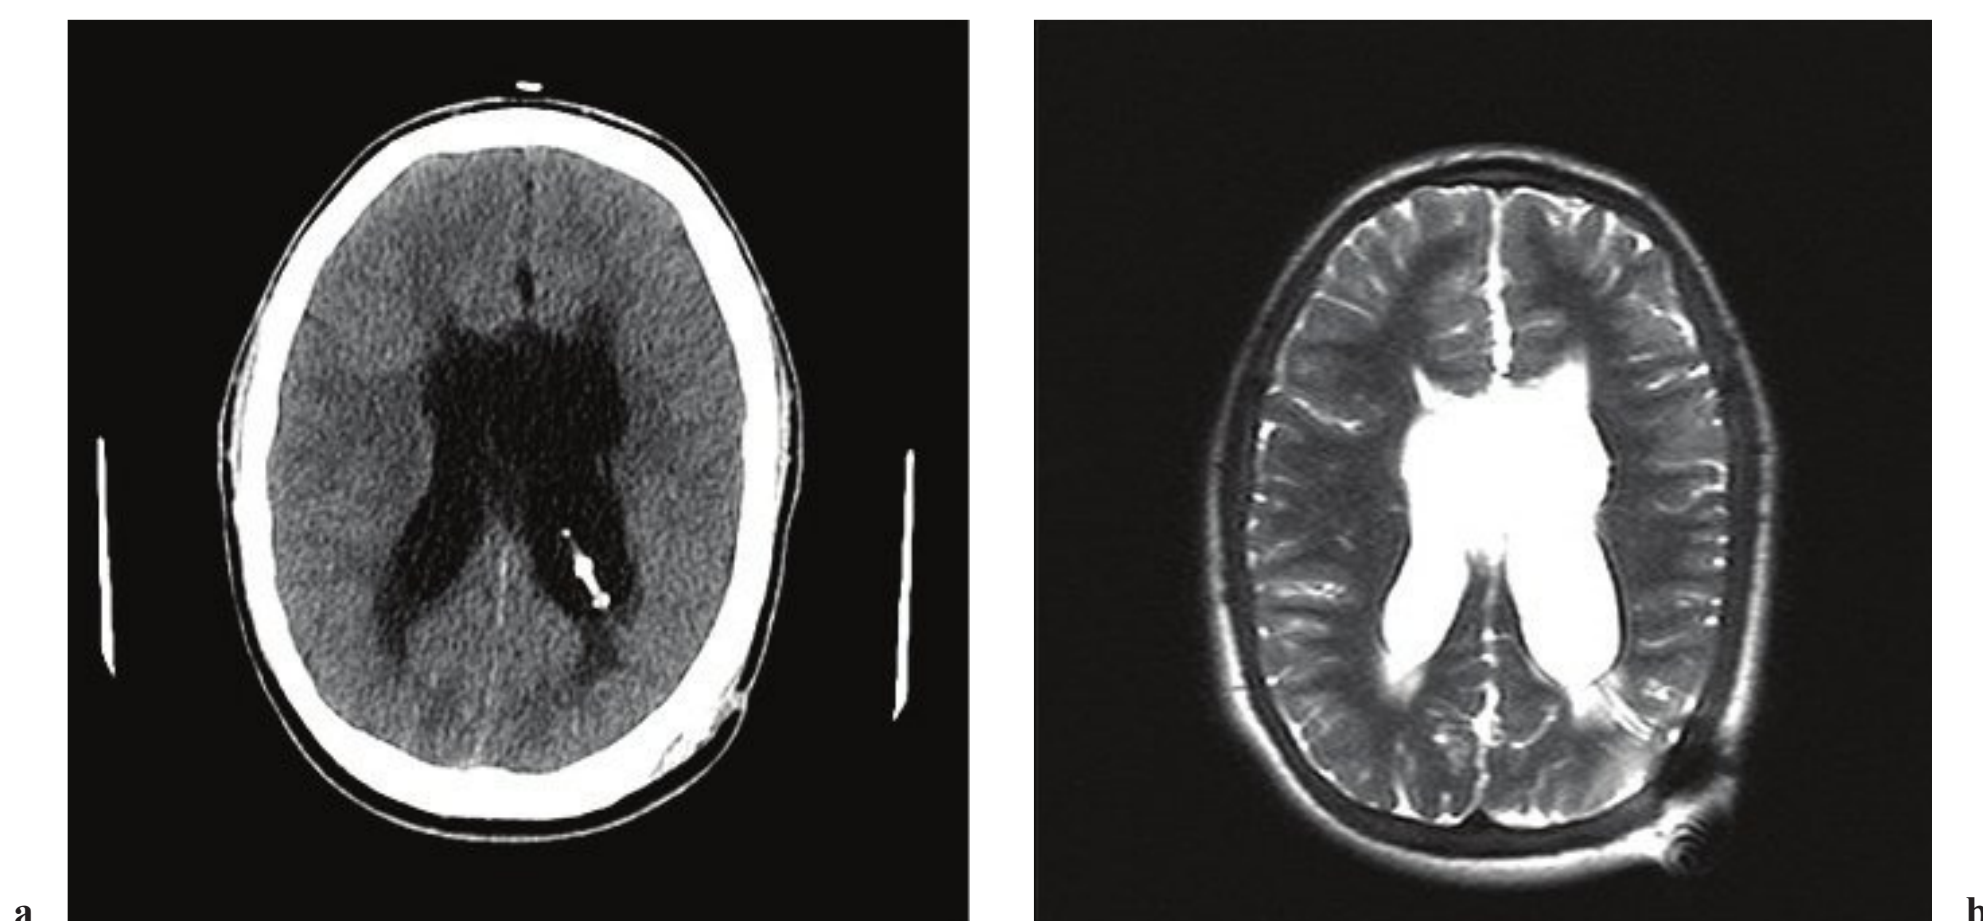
Preoperative imaging of shunt malfunction of the same patient. (a) Head CT and (b) brain MR (Haste T2 protocol).
